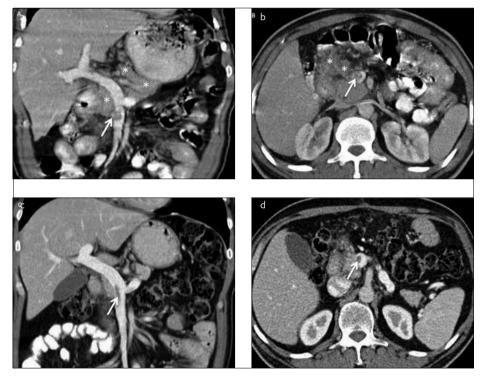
a-d. A 58-year-old woman with gastric cancer invading the superior mesenteric vein. Coronal (a) and axial (b) CT images demonstrating tumoral infiltration through the course of the right gastroepiploic vein (asterisks, a, b). Superior mesenteric vein invasion is also seen at the side of gastroepiploic vein drainage (arrows, a, b). Follow-up CT (c, d) after chemotherapy reveals marked tumoral regression at the course of the right gastroepiploic vein. Residual bland thrombus is seen without any sign of enhancing the soft tissue mass (arrows, c, d)
